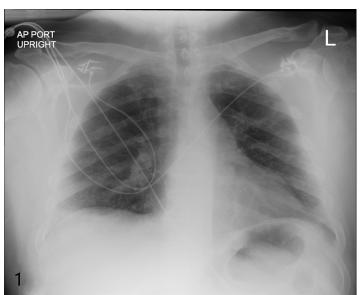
Clear anterior posterior portable chest radiograph taken in the emergency department.
